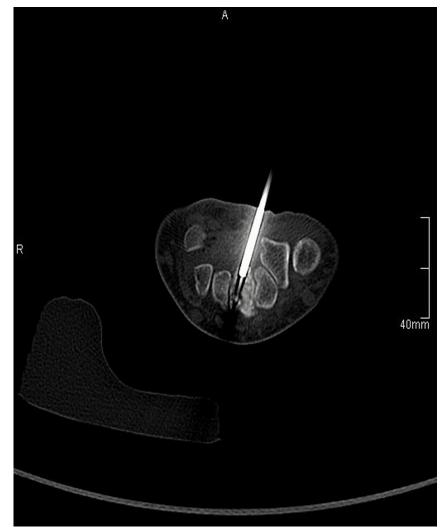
CT - guided percutaneous thermal ablation was performed for the this patient, the axial image shows the needle in place targeting the osteoid osteoma nidus.
